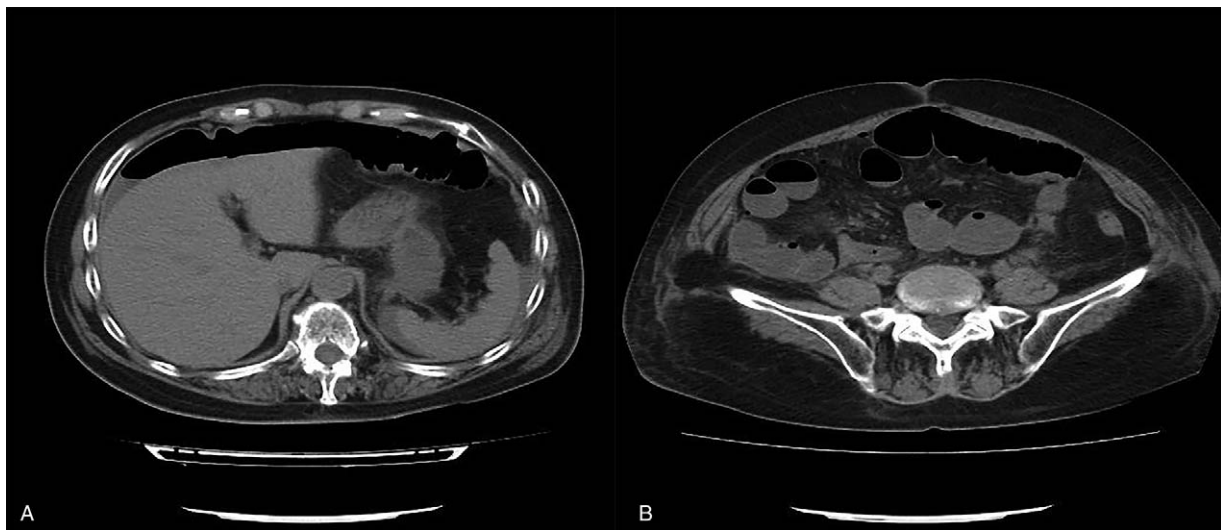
Abdominal contrast-enhanced computed tomography revealed free gas in the abdominal cavity and peritoneal fluid (Fig. 1a). Abdominal CT also revealed a right lateral abdominal wall disruption in the iliac crest area involving the internal oblique muscles and the fascia, with no internal organ herniation through the defect (Fig. 1b). CT = computed tomography.
